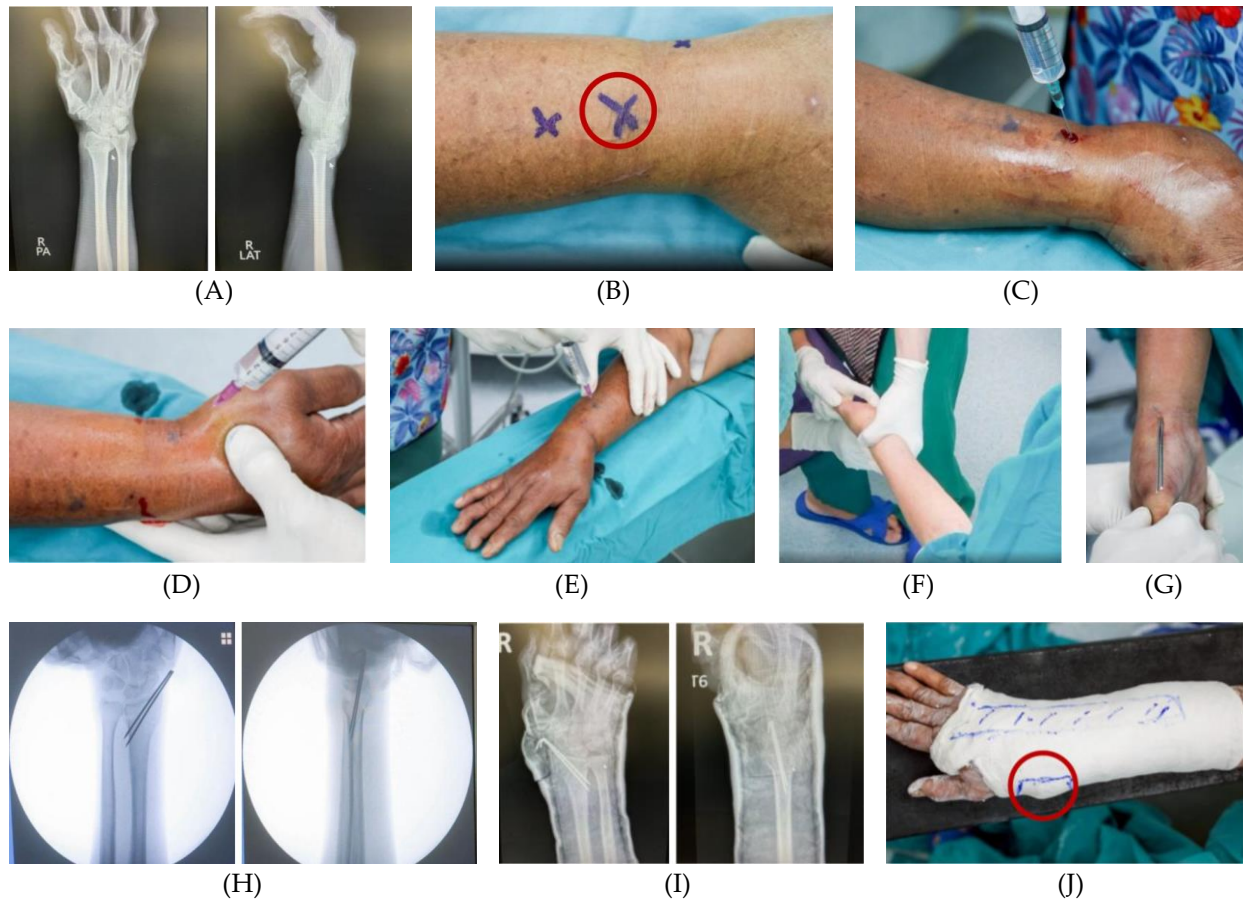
Surgical procedure of local anesthesia (LA) via a combined hematoma block with percutaneous site infiltration. (A) Preoperative plain radiographs (anteroposterior and lateral views) demonstrate a displaced distal radius fracture before reduction. (B) Three planned injection sites marked on the skin surface: fracture hematoma entry point (circle), planned K-wire entry point (x), and planned K-wire exit point (x). (C) Hematoma block injection administered via a 21-gauge needle advanced dorsally into the fracture hematoma. (D) Percutaneous infiltration at the planned K-wire entry point. (E) Percutaneous infiltration at the planned K-wire exit point. (F) Closed reduction performed under manual traction-countertraction technique. (G) Percutaneous K-wire fixation with wires in situ. (H) Intraoperative fluoroscopic images confirm acceptable fracture reduction and K-wire placement. (I) Postoperative plain radiographs (anteroposterior and lateral views) demonstrate satisfactory reduction. (J) Short-arm circumferential cast with two windows marked on the cast surface: a longitudinal window along the K-wire track (dashed line, to facilitate rail-road slit for pressure relief) and a circular window over each K-wire entry site (circle, for daily pin-site wound care).
